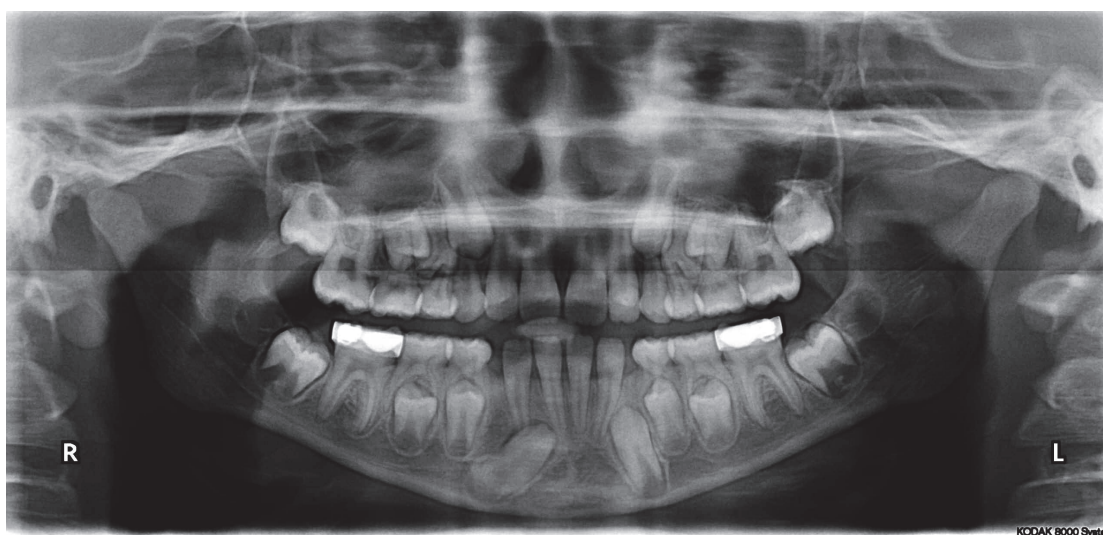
An initial orthopantomogram.
